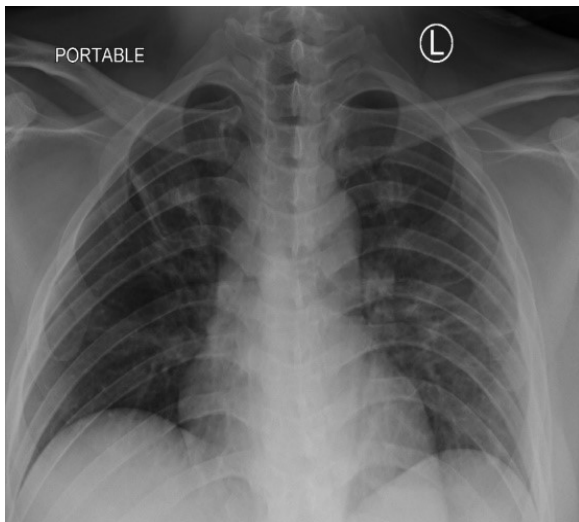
Chest radiograph 7 days post treatment showing significant clearing of bilateral lung consolidations.
